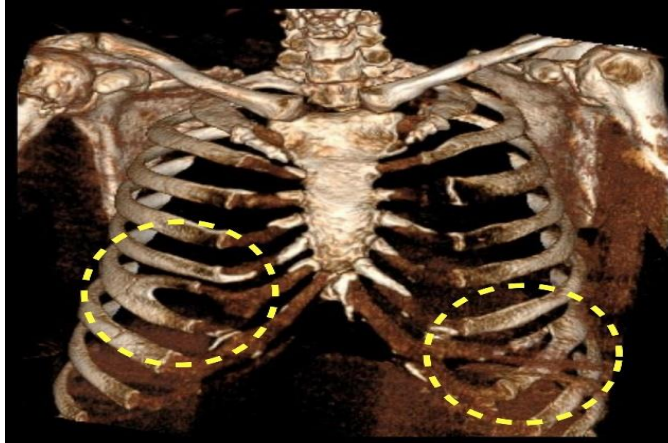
Three-dimensional reconstruction of computed tomography images indicated bilateral bifid costae.
